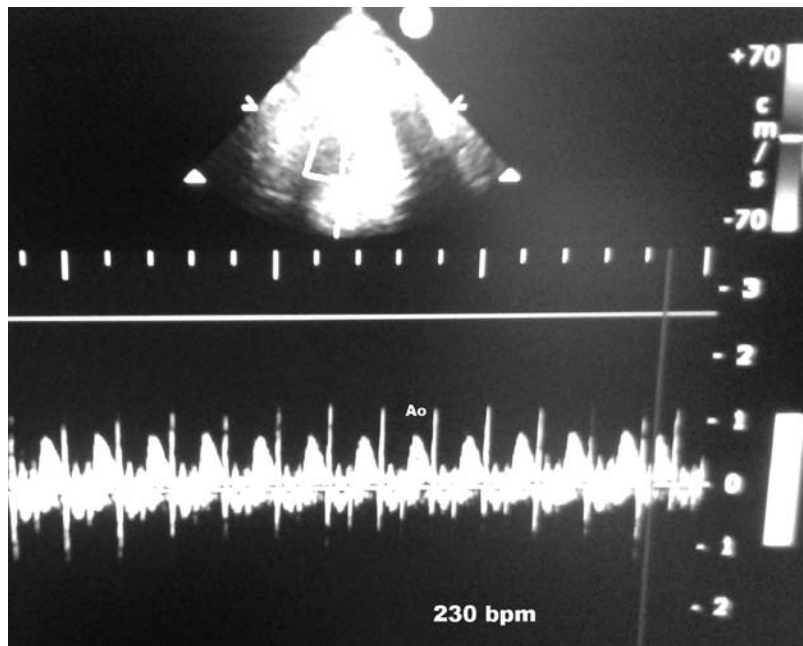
Fetal heart rate in the Doppler examination obtained from aortic flow is 230 bpm.
